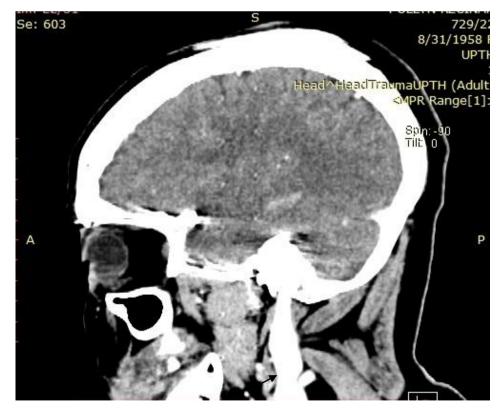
Contrast coronal CT showing a markedly dilated and tortuous left IJV (indicated by the arrow)
